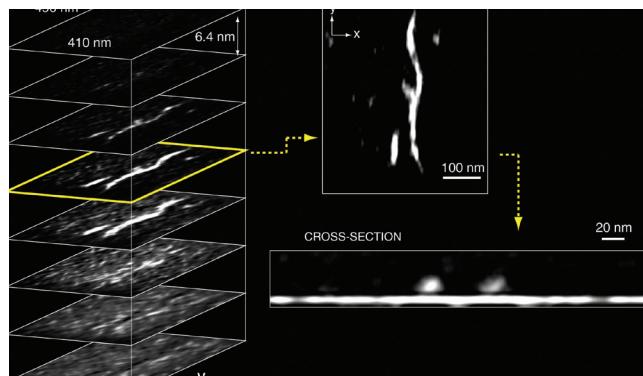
Three-dimensional MRI of several viral fragments lying on a surface covered by a thin film of organic molecules. Pictures to the right show a horizontal and a vertical cut through the 3D image.
